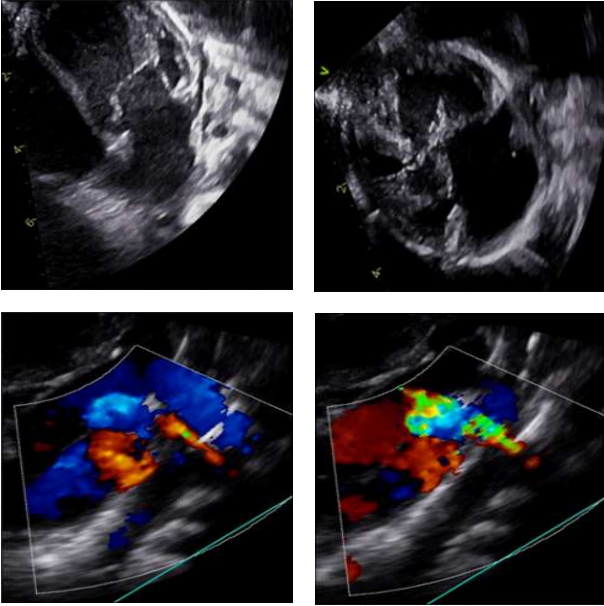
Ultrasound video frames corresponding to congenital heart defects in newborns, such as structural abnormalities and defects in large blood vessels.
